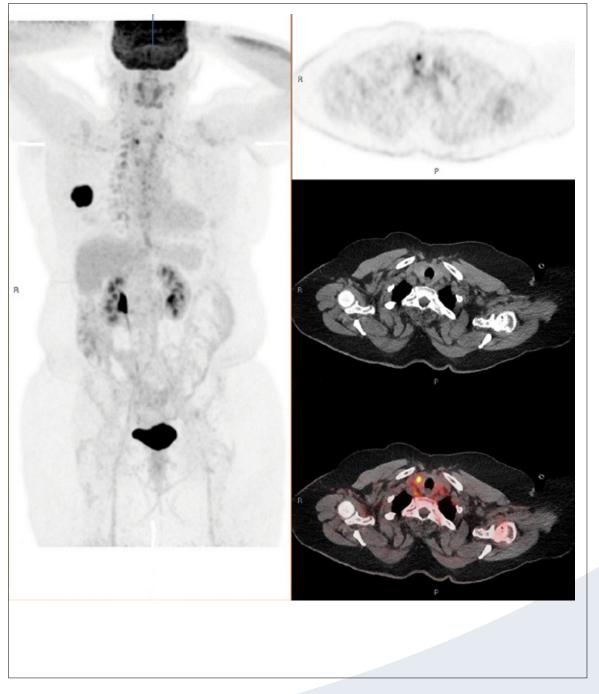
Example patient case with an encountered incidental finding. [¹⁸F]FDG PET/CT showed, in addition to the breast tumour without lymph node or distant metastasis, a suspected thyroid lesion. This lesion appeared to be a follicular adenoma after an inconclusive biopsy and later diagnostic hemithyroidectomy.
